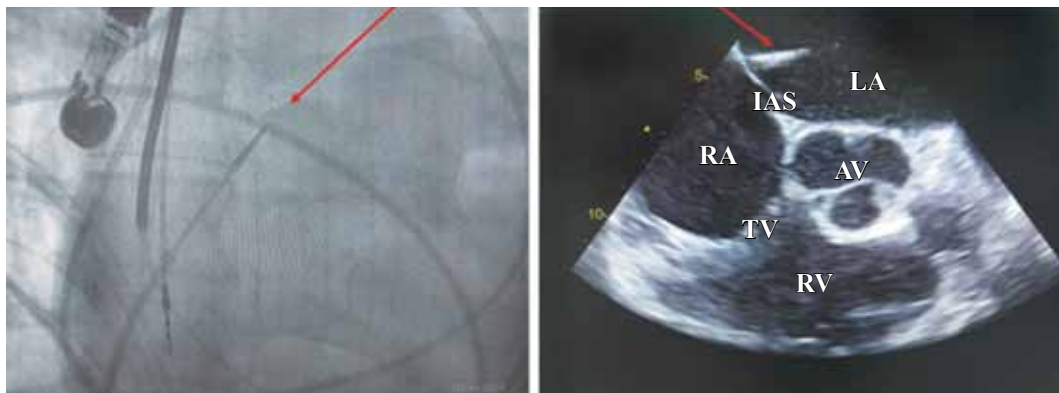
Image-guided transseptal puncture for access to the left atrium and insertion of transseptal catheter (8.5 F diameter, indicated by red arrows) into its cavity using echocardiographic-fluoroscopic fusion imaging. AV, aortic valve; LA, left atrium; IAS, interatrial septum; RV, right ventricle; RA, right atrium, TV, tricuspid valve
